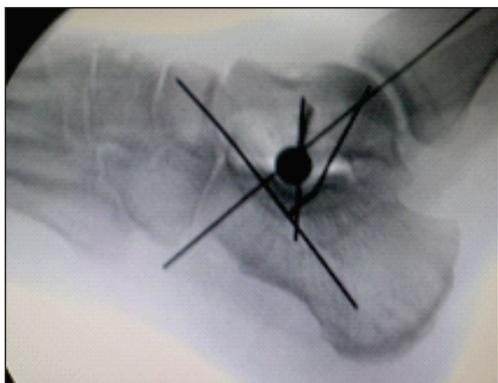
shows intraop X-rays insertion of ARTROM GMREIS arthroereisis screw.
